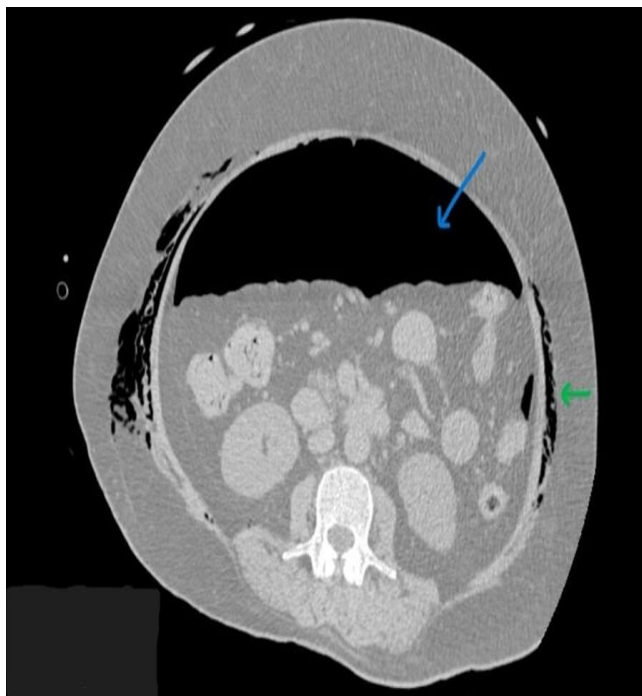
CT scan of the abdomen showing Pneumoperitoneum (blue arrow) and subcutaneous emphysema (green arrow)
